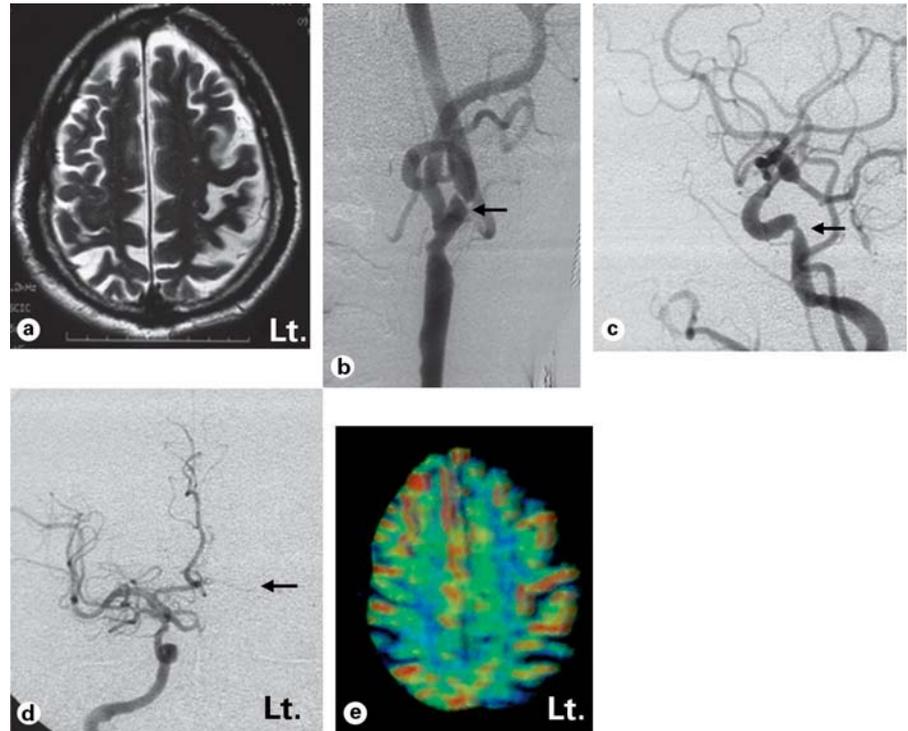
Pre-operative evaluation of case 1. a MRI (T₂WI) which showed no infarction in SM1. b DSA of left carotid artery at the cervical bifurcation (lateral view) showing 95% stenosis (arrow) on NASCET measurement. c DSA of left intracranial ICA (lateral view), indicating stenosis of C4-5 portion (arrow). d DSA of right intracranial ICA (A-P view), showing minute cross-flow through anterior communicating artery to left anterior cerebral artery. e Xenon CT after infusion of acetazolamide, showing decreased CBF in left MCA territory.
